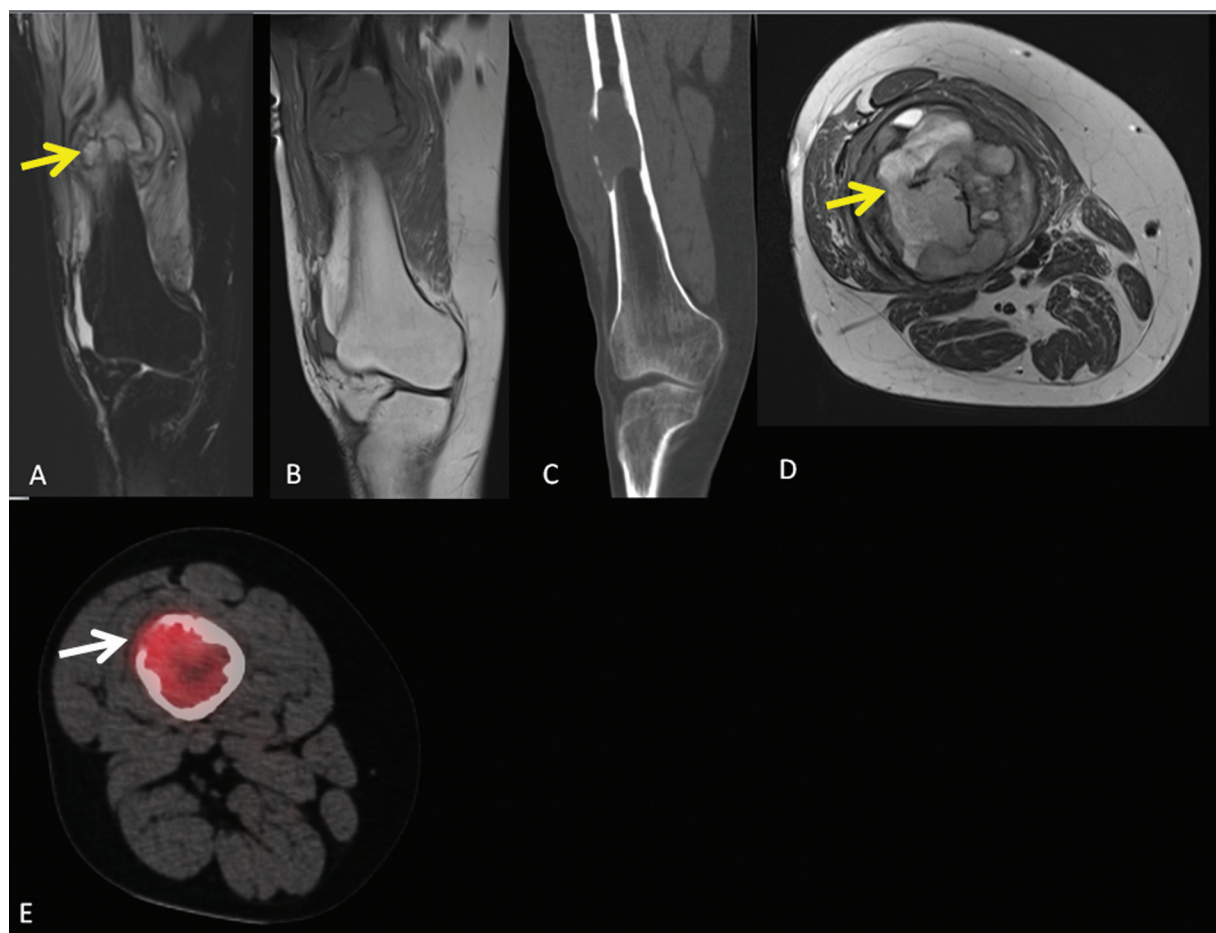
Coronal STIR MRI (A), T1 MRI images (B), Coronal CT (C) and axial T2 MRI(D) images reveals heterogeneous hyperintense lesion (yellow arrows) involving the mid-shaft of the right femur with associated cortical erosions and breach with adjacent metabolically active soft tissue component with SUVmax-6.8 on PET-CT (white arrows-E) images. Abbreviations- Magnetic resonance imaging (MRI), Position emission tomography-computed tomography (PET-CT), short tau inversion recovery (STIR), maximum standard uptake value (SUVmax).
